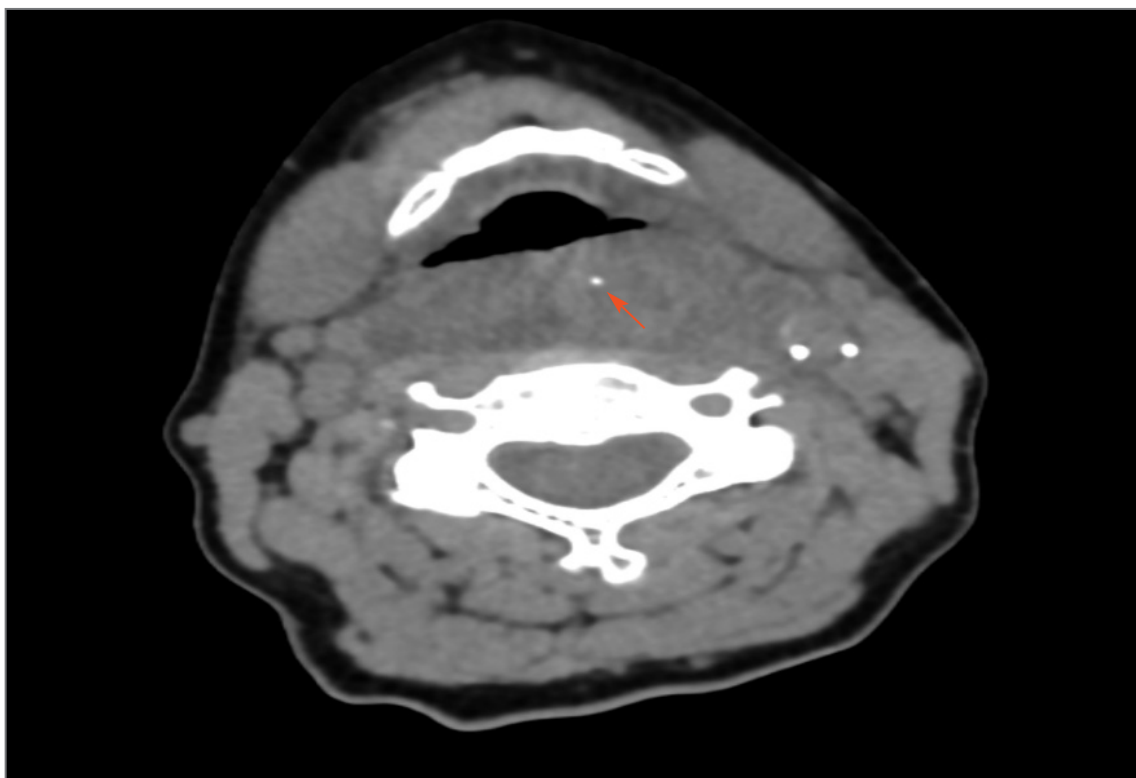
CT scan, axial section, foreign body – fish bone 15 mm – arrow
